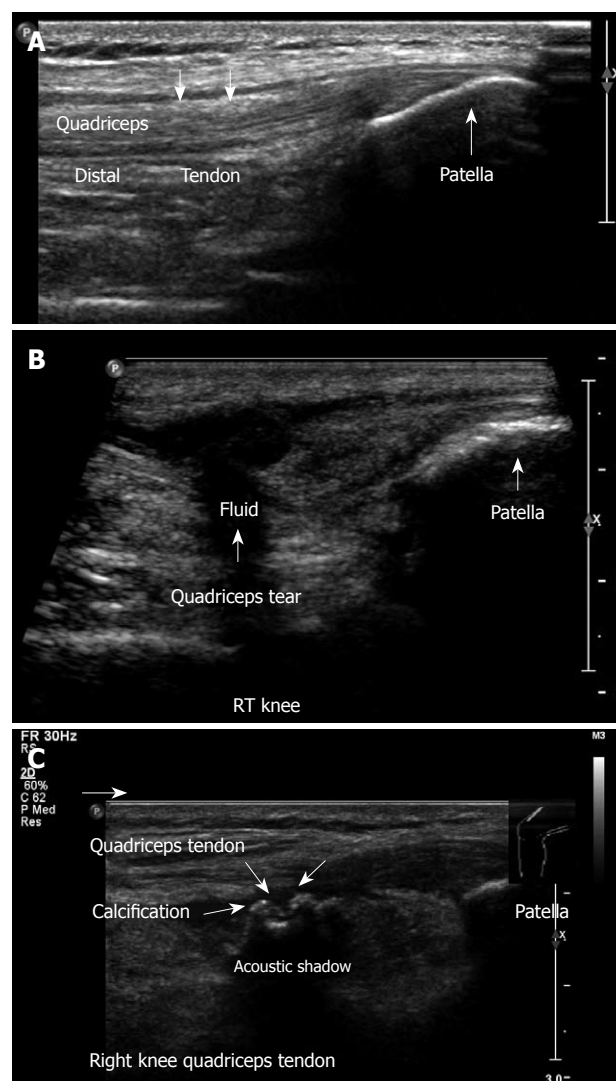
Anterior knee. A: Longitudinal ultrasound image obtained in the midline, demonstrating the anterior knee, quadriceps tendon with its insertion to the patella, suprapatellar recess, and the patella. No effusion is visible; B: Longitudinal view. Complete quadriceps tendon tear. This 62-year old physician suffered direct trauma to his right knee when falling down stairs; C: Quadriceps tendinitis with calcification of the right knee. This 50-year old man had a contusion with hematoma of the quadriceps muscle one year ago.
